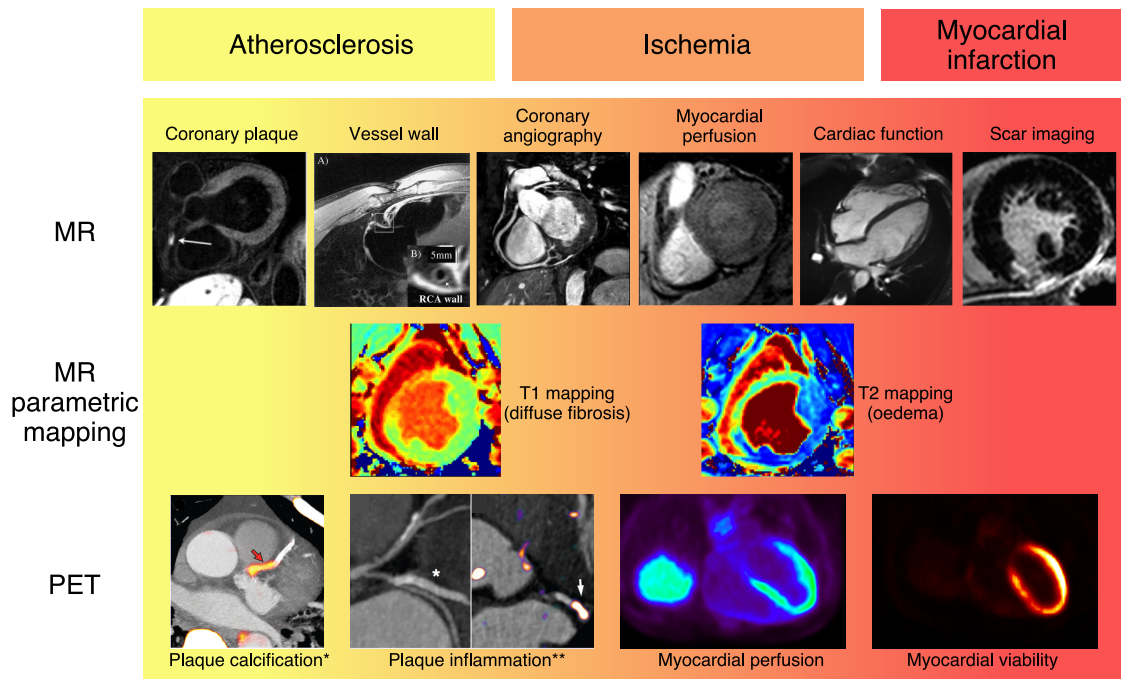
Role of PET and MR imaging in the diagnosis and monitoring of CAD progression. Plaque location and composition can be visualised by both PET and MR, while visualisation of the vessel wall integrity is a promising technique in MR. After the onset of ischaemia, both modalities offer great potential for assessing the extent of the hypoperfused areas in the myocardium, while MR allows for visualisation of the coronary lumen and evaluation of cardiac function. After myocardial infarction, MR can be used for scar imaging, while myocardial viability PET can be used for predicting potential functional recovery in the myocardium. Throughout the development of the disease, quantitative MR techniques such as T1 and T2 mapping allow for detection of diffuse fibrosis and oedema in the myocardium, respectively. *Adapted with permission from Joshi N.V. et al. *¹⁸F-fluoride positron emission tomography for identification of ruptured and high-risk coronary atherosclerotic plaques: a prospective clinical trial*. The Lancet 2014;383:705–13 [8]. Adapted with permission from Tarkin J.M. et al. *Detection of Atherosclerotic Inflammation by ⁶⁸Ga-DOTATATE PET Compared to [¹⁸F]FDG PET Imaging*. Journal of the American College of Cardiology 2017;69:1774–1791 [9].
